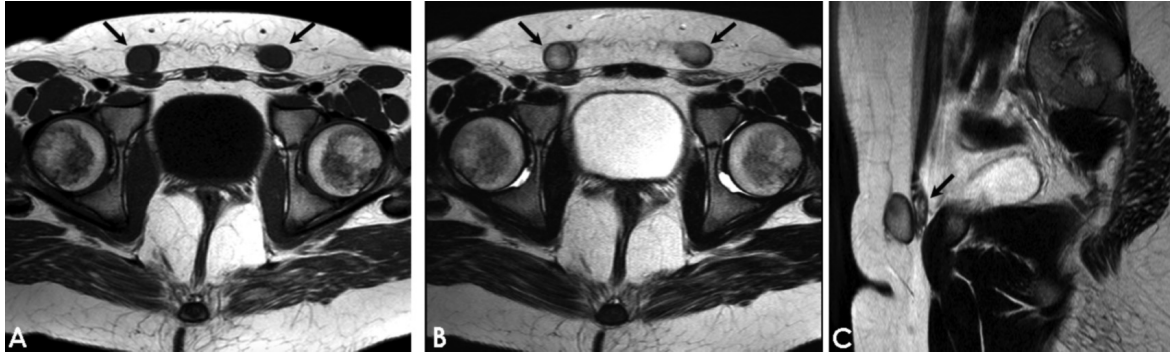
(A-B) Axial T1- and T2-weighted images reveal bilateral solid nodular structures with homogeneous, mild hyperintensity in the anterior lower pelvic wall, adjacent to the external inguinal ring, compatible with testes (black arrow); (C) Sagittal T2 TSE image shows subtle, hyperintense, tubular structure similar to atrophic epididymides behind the gonads (black arrow).
